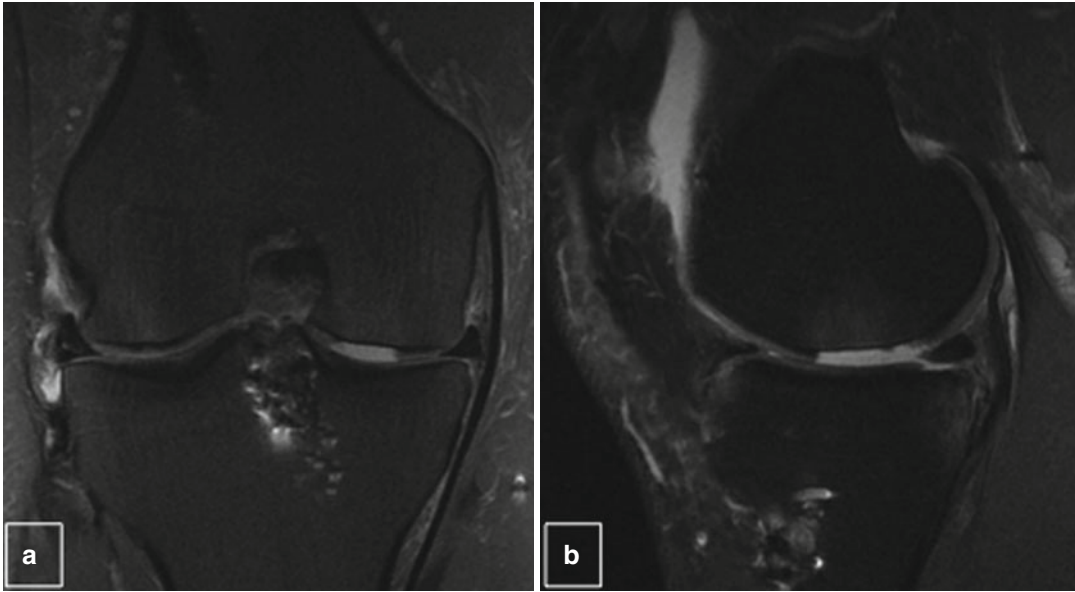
(a) Frontal and (b) sagittal MRI view showing a cartilage lesion of the medial condyle
